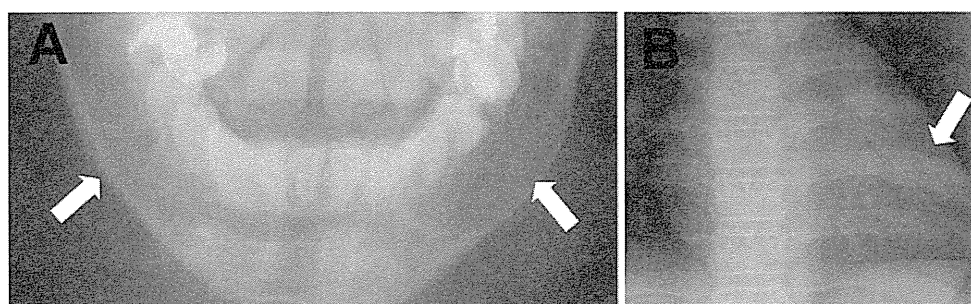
Roentgenograms of the patient. a Pantomography shows bilateral keratocystic odontogenic tumors (Arrows). b Chest roentgenogram reveals a bifid anomaly of the left sixth rib (Arrow)
